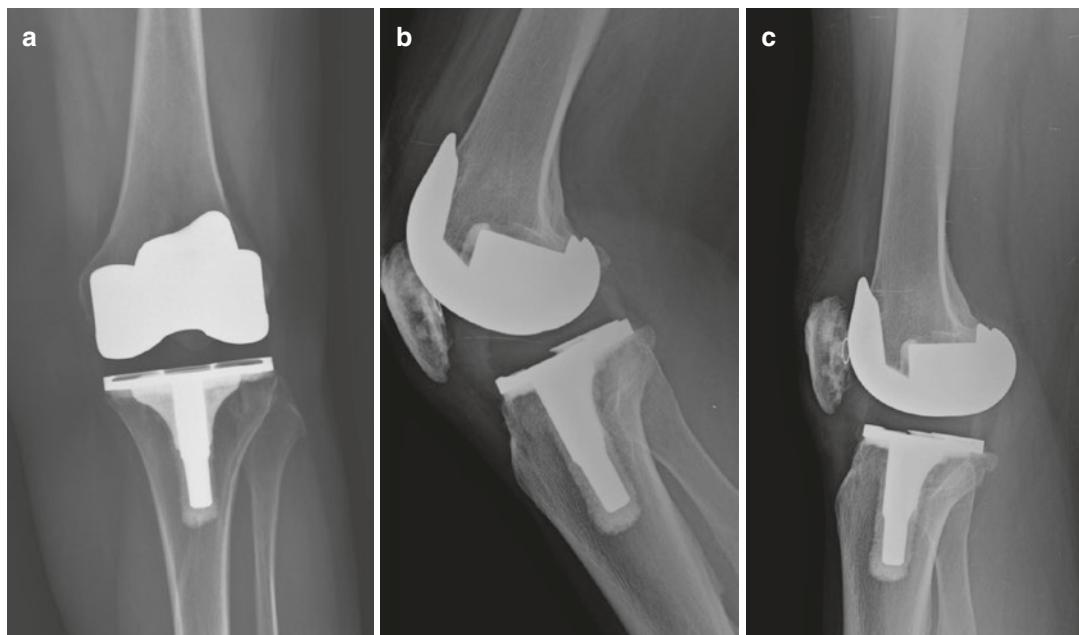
Follow-up (a) anteroposterior and lateral radiographs, in (b) flexion and (c) extension 1 year after polyethylene liner exchange
